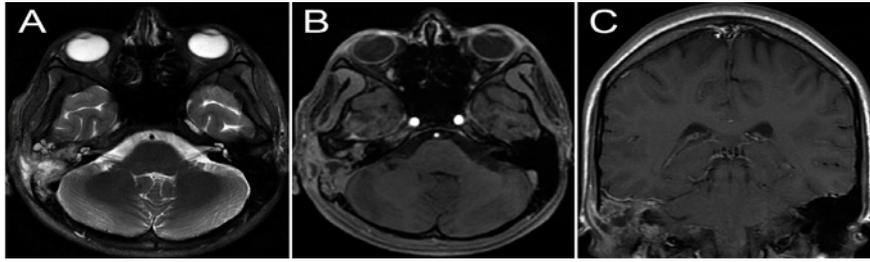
Axial T2-weighted MRI shows a hyperintensity at the mastoid process of the right temporal bone.
